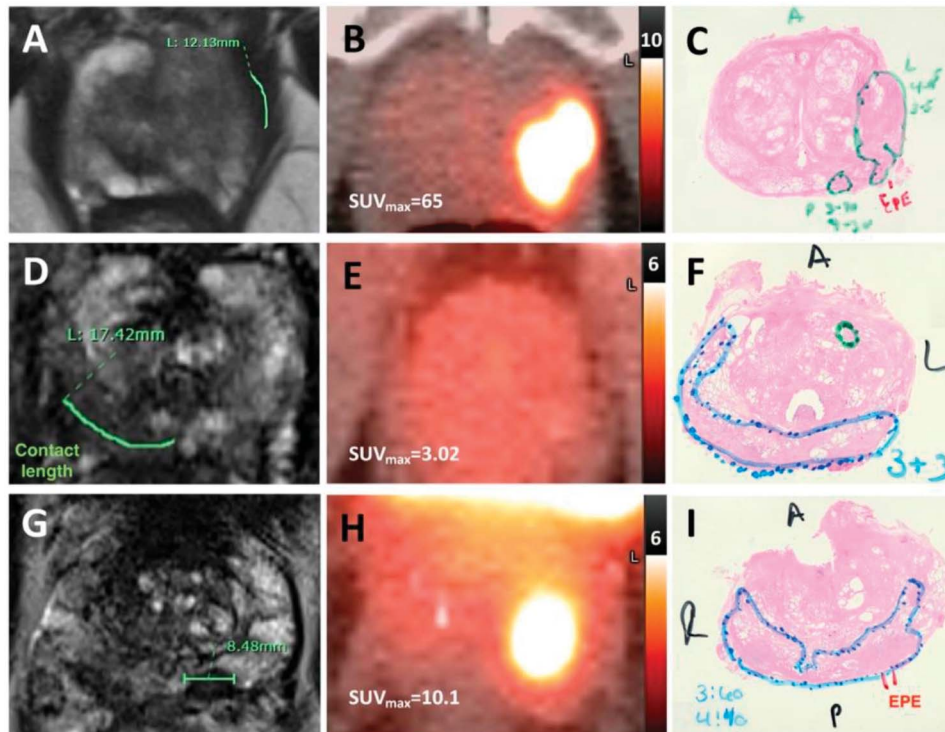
Comparison of multiparametric MRI, PSMA-PET (⁶⁸Ga-prostate-specific membrane antigen-11 positron emission tomography CT), and whole mount for 2 cases. The first case (A to C) demonstrates a 74-year-old with PSA 14.3 ng/mL and a 53-cm³ prostate (PSA density 0.27) with biopsy showing 4 + 4 prostate cancer (3 cores in left mid and apex). The MRI (A) was read as left anterior apical lesion without extraprostatic extension (EPE) at the neurovascular bundle while the PSMA-PET (B) was read as likely left-sided EPE at the neurovascular bundle. The final pathology (C) confirmed left EPE. The second case (apex: D-F, base: G-I) demonstrates a 66-year-old with PSA 6.8 ng/mL and a 42-cm³ prostate (PSA density 0.16) with biopsy showing 3 + 3 at the right apex and 4 + 3 at the base. The MRI (D) was read as right apical EPE, while the PSMA-PET (E) and final pathology (F) did not show EPE at the apex. The MRI (G) did not predict EPE at the base, while the PSMA-PET (H) and final pathology (I) showed EPE at the left base. SUVmax indicates maximum standardized uptake value.
